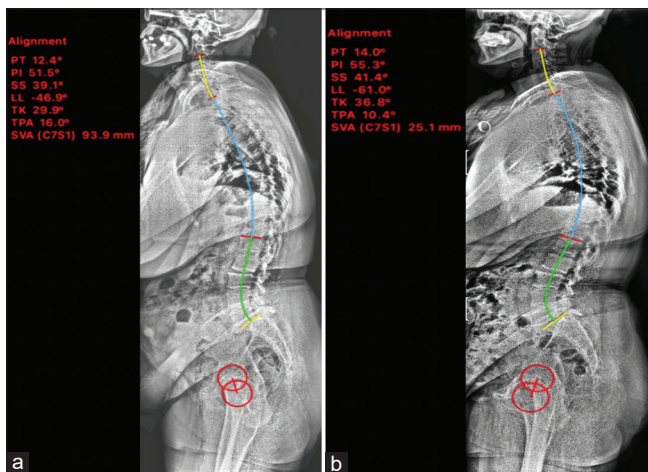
Preoperative and postoperative spinopelvic parameters of one patient measured via Surgimap program. whole spine radiograph before surgery (a) and after surgery (b), red circles represent femoral heads. There was an increase in lumbar lordosis, increase in thoracic kyphosis, and decrease in sagittal vertical axis values. PT - Pelvic tilt, PI - Pelvic incidence, SS - Sacral slope, LL - Lumbar lordosis, TK - Thoracic kyphosis, TPA - T1-pelvic angle, SVA - Sagittal vertical axis
